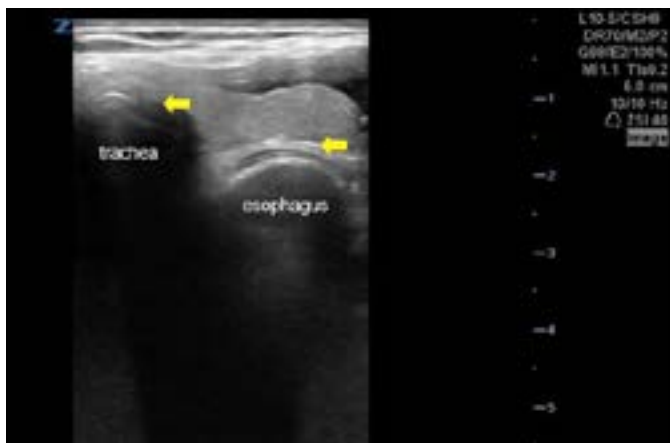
Linear ultrasound probe placed transversely on the patient's neck identified an inadvertent esophageal intubation with the "double tract" sign (yellow arrows).
